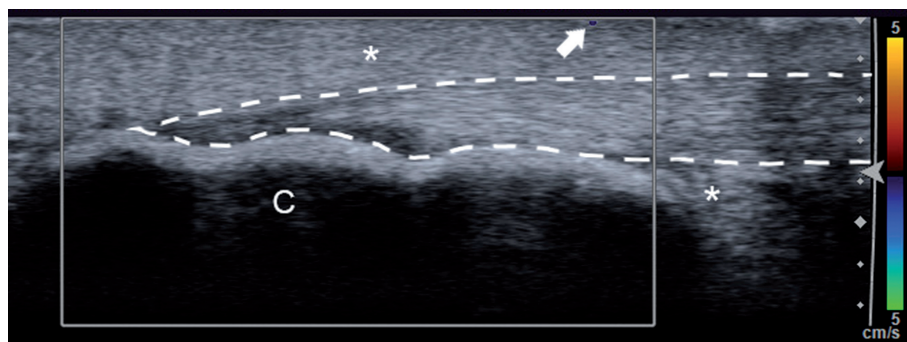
Ultrasound and Color Doppler examination of healthy Achilles tendon insertion. The calcaneus is clearly visible (C), and a single subcutaneous vessel is visualized by Color Doppler (arrow). No clear demarcation of the bursae is evident (asterisks). The dashed line marks the contour of the Achilles tendon.
